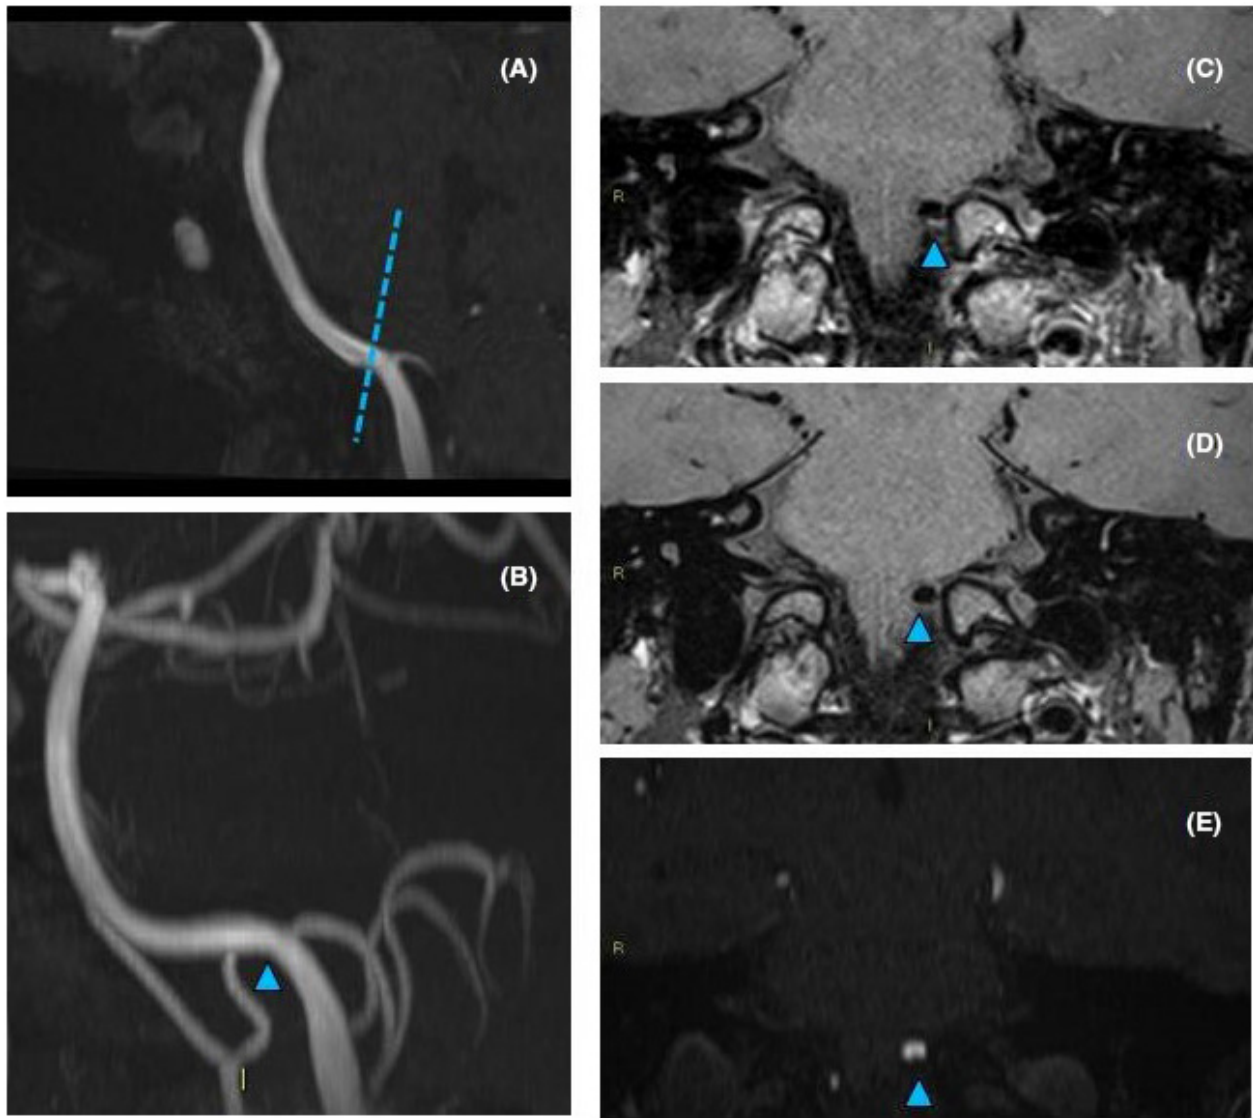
Neuro-radiological findings of migraine patient #2, focused on left vertebral artery. (A) Sagittal reconstruction of 3D time of flight (TOF) sequence of the intracranial left vertebral artery with blue dotted line across the emergency of the postero-inferior cerebellar artery (PICA), representing the plane of section of panels C, D, and E. (B) Maximum intensity projection sagittal oblique reconstruction of the same TOF sequence (thick slices of 10 mm) where the blue arrowhead shows the presence of a mild stenosis at the emergence of the PICA. High resolution vessel wall magnetic resonance imaging with (C) and without (D) contrast medium in a transverse section passing through the dotted line of image A, showing the presence of a mild contrast enhancement at this level (blue arrowheads). (E) Maximal production rate coronal reconstruction of the same 3D TOF sequence showing the presence of a mild notch in the inferior portion of the vertebral artery lumen (blue arrowhead), at the level of the emergence of the PICA (blue dotted line in A)
